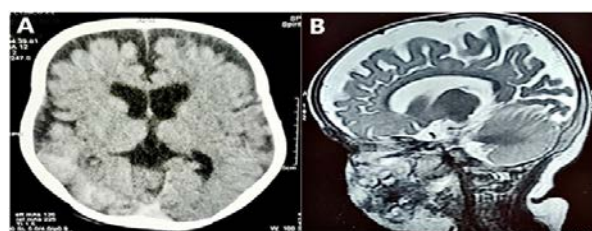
A: CECT scan of brain reveals cortical hyperdensities in right occipito-temporo-parietal region and moderate enlargement of third and lateral ventricles; B: MRI reveals diffuse prominences of cerebral sulci. Spaces in bilateral fronto-temporo-parietal region. No blooming seen on GRE
